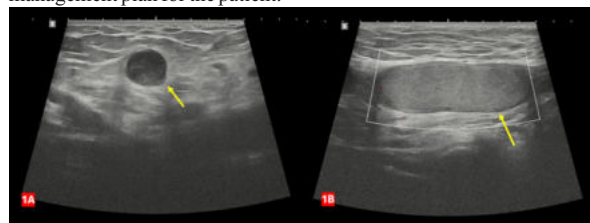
1A shows diffuse hypoechoic Edematous spermatic cord. 1B figure shows left testis with altered echotexture while on colour doppler shows absent colour flow.
